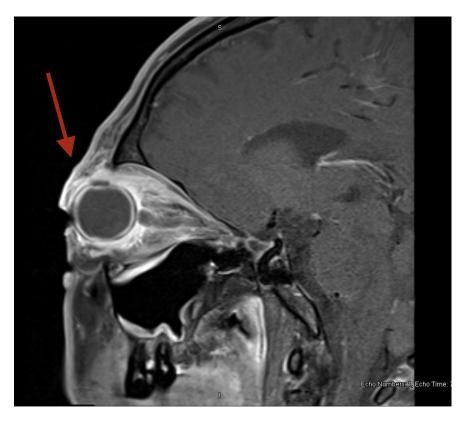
T1 weighted sagittal post-contrast MRI orbit showing right pan-orbital enhancement (marked by red arrow).
